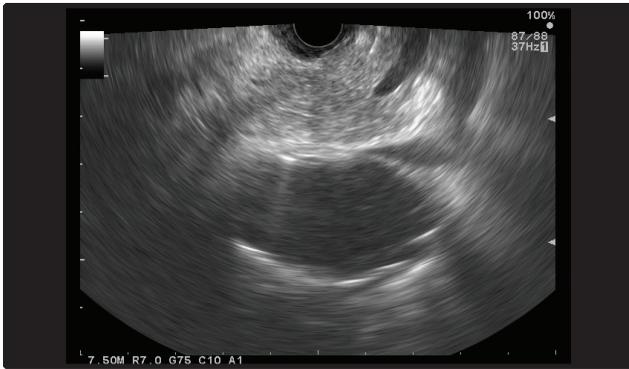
Jaundiced patient without mass on CT underwent EUS, showing no mass, but caliber change in the CBD and PD (shown here). FNA done (needle indicated by arrow) diagnostic for pancreatic adenocarcinoma.
